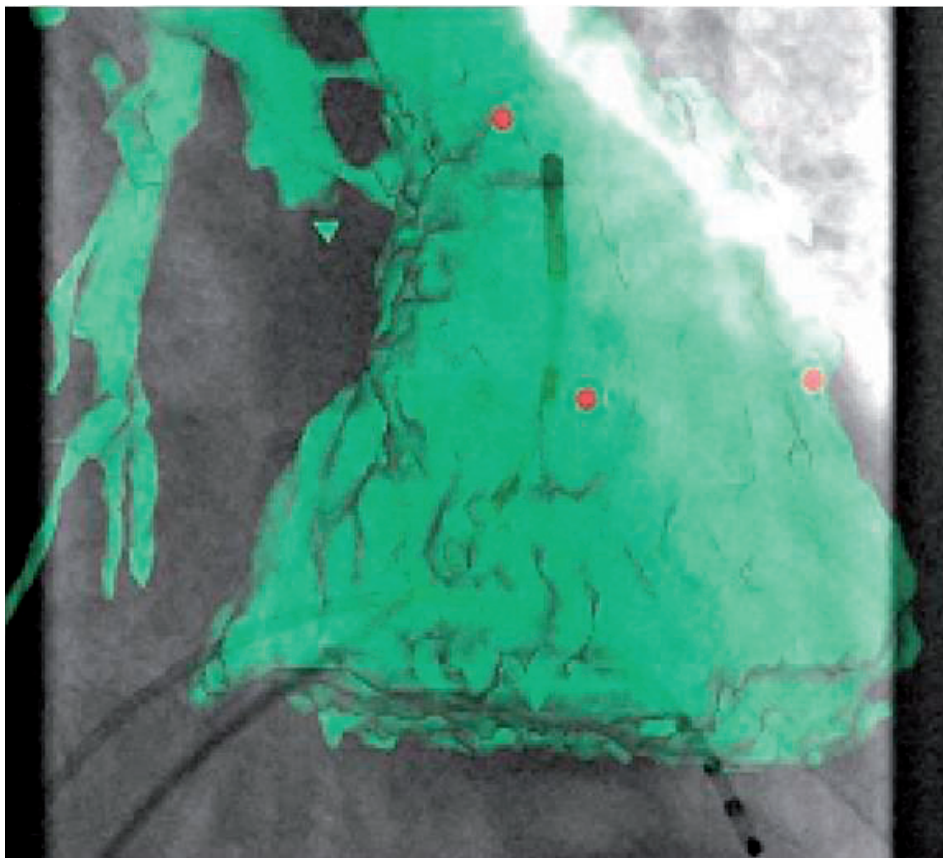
Image integration of fluoroscopy, with an ablation catheter in the right ventricular outflow tract, and a computed tomography of this region, in which the catheter is navigated.
